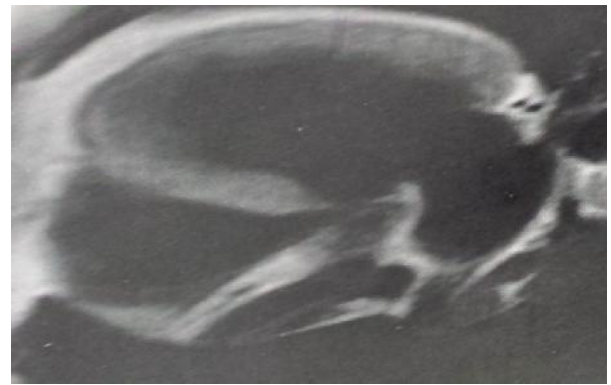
Cardiac MRI showing a dilated LV and inflammatory wall
